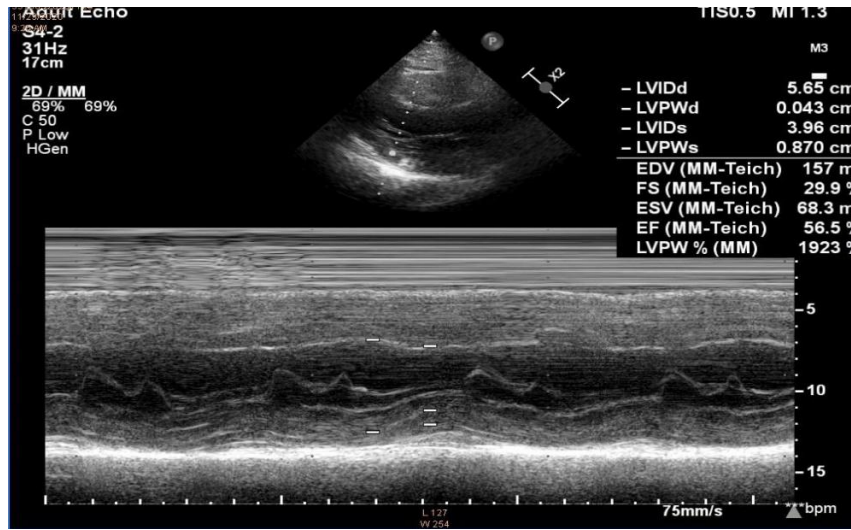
Echocardiography: EF56%. MILD MR, diastolic dysfunction grade, no SWMA at rest.
